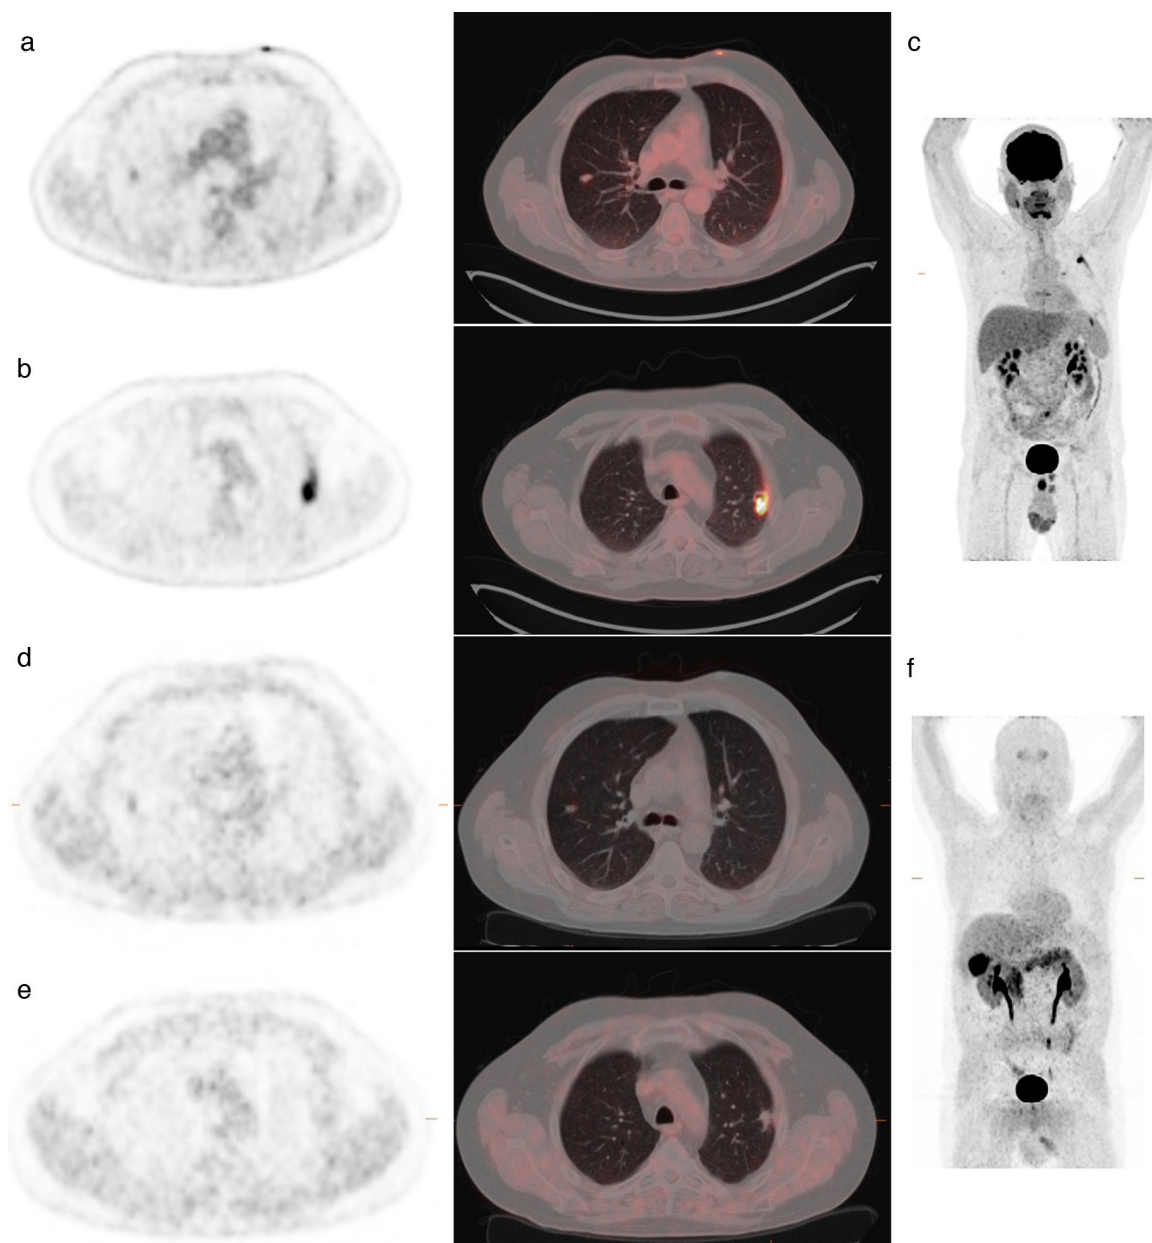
Upper panel. 18F-FDG-PET/CT performed after the injection of 259 MBq of radiotracer. (a) Pulmonary nodule located in the right-upper-lobe with SUVmax 1.9. (b) A second pleural-based pulmonary nodule was located in the left-upper-lobe with SUVmax 10.3. (c) Maximum intensity projection of 18F-FDG-PET/CT scan. Lower panel. 18F-DOPA-PET/CT acquired after the injection of a dose of 233 MBq. (d) Solitary pulmonary node showed in the right-upper-lobe with SUVmax 1.1. (e) 18F-DOPA-PET/CT allowed discarding the contralateral and pleural involvement. (f) Maximum intensity projection of 18F-DOPA-PET/CT scan revealing pancreatic physiological uptake due to no administration of carbidopa before the injection of radiotracer.
